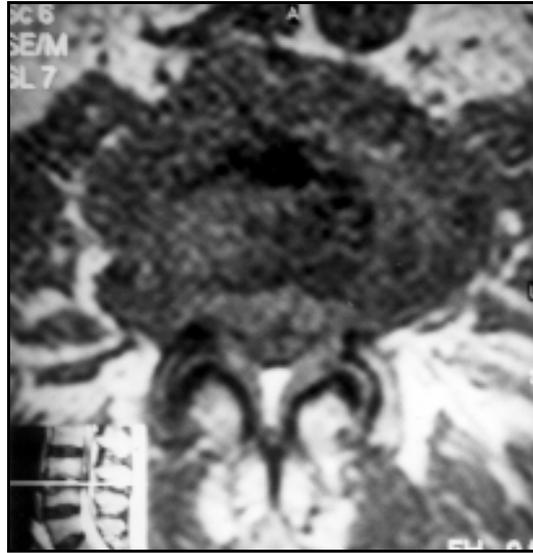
Axial T1 weighted MR images at the level of the third and fourth intervertebral disc space revealed vacuum sign and contrast enhancement of the disc suggesting spondylodiscitis.
